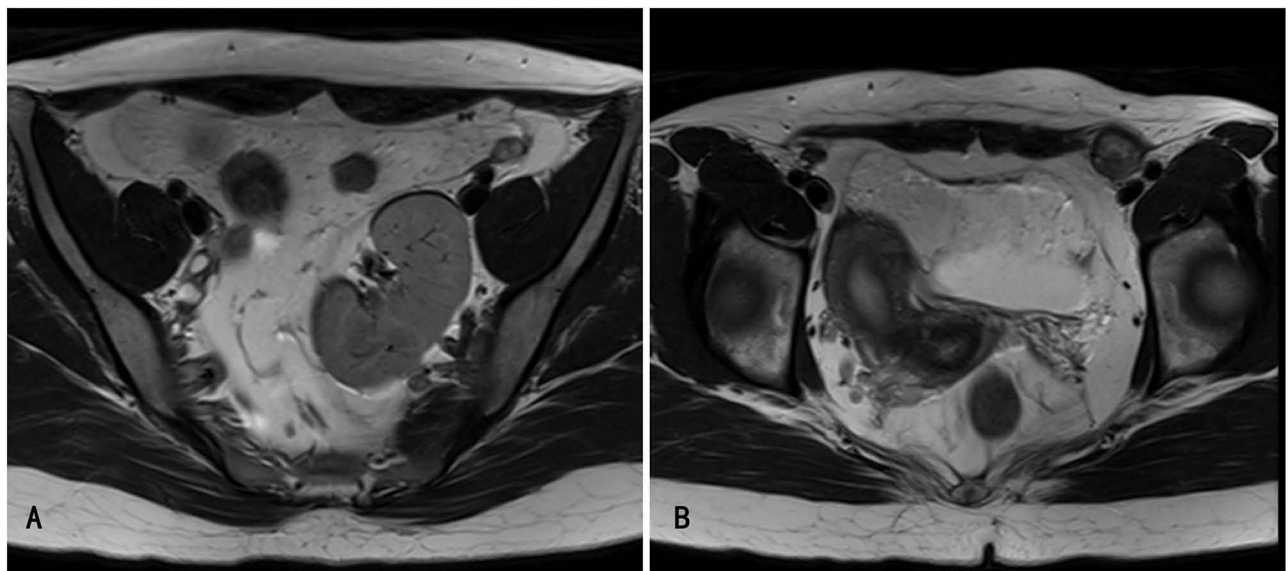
(A) Pelvic kidney on MRI. (B) Pelvic MRI reveals a unicornuate uterus and an inguinal-region mass.
